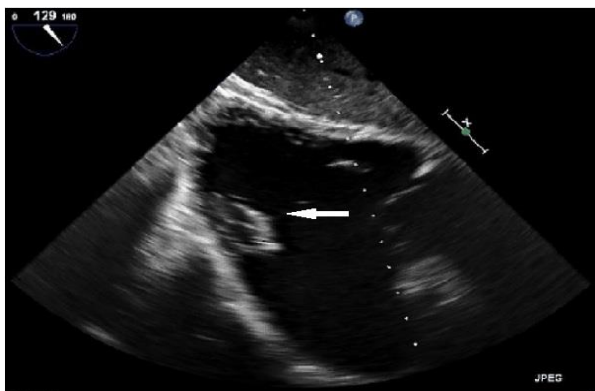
Two-dimensional transesophageal echocardiogram in case 1, in transgastric right ventricle view showing only single papillary muscle (white arrow)
